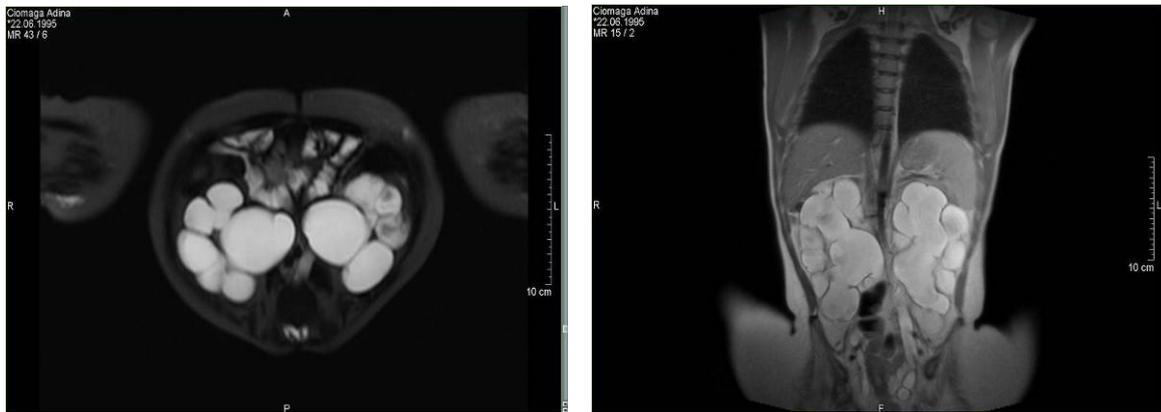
C Adina’s MRI: neuropathic bladder and bilateral ureterohydronephrosis.
